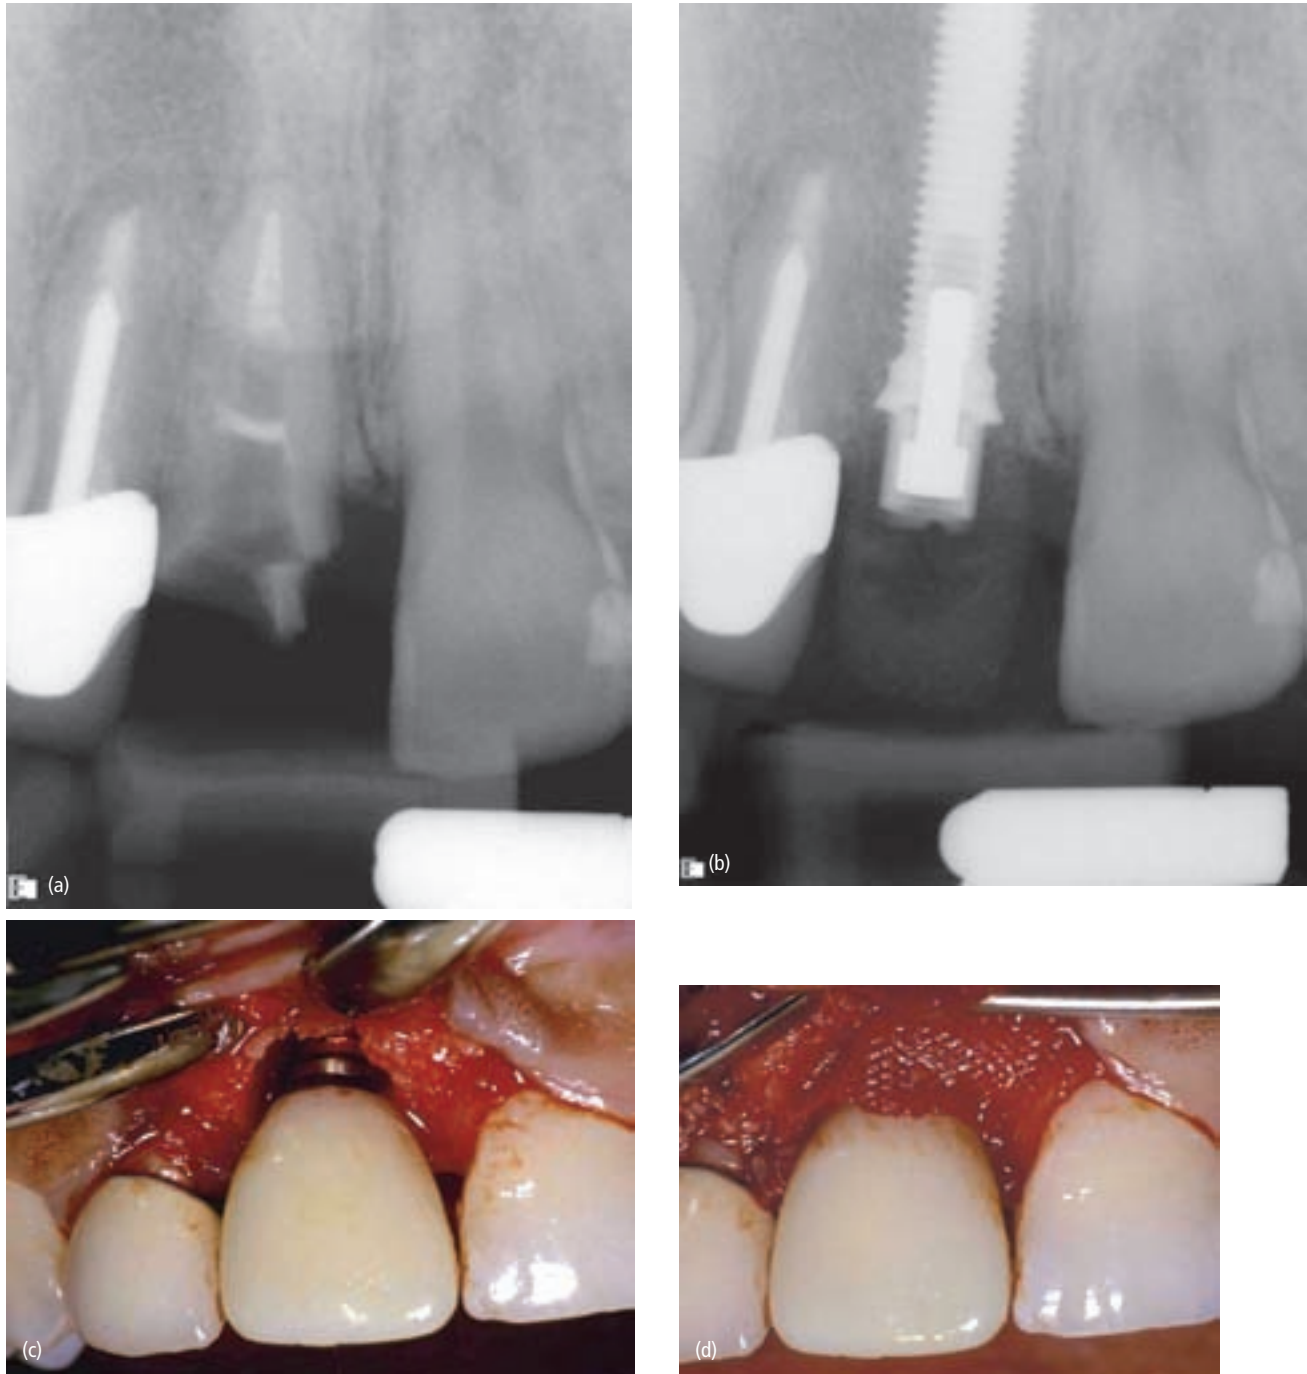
(a) A root fracture of the maxillary right central incisor can be seen on this radiograph. (b) An immediate implant was placed after extraction and débridement of the socket, and an abutment was affixed at the time of surgery. (c) After fabrication of the provisional restoration (cemented with a strong cement to prevent loosening) a bone allograft was tightly packed between the implant and the alveolus. (d) A PG910 membrane was placed over the graft material external to the alveolar housing and contoured interproximally.
